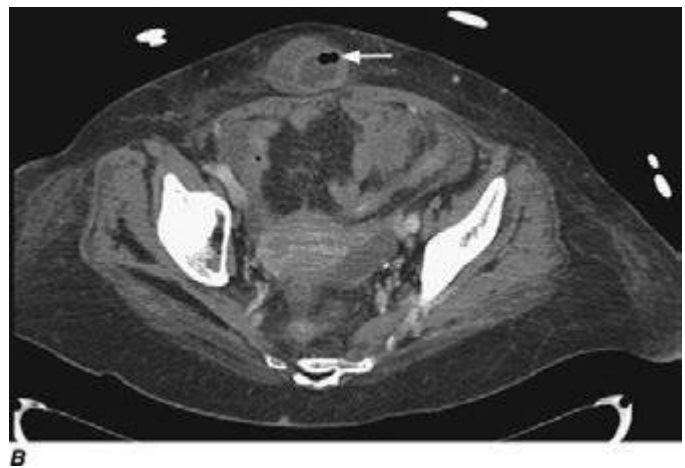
Computed tomography with oral and intravenous contrast demonstrating (A) evidence of small-bowel dilatation with air-fluid levels consistent with a small-bowel obstruction; (B) a partial small-bowel obstruction from an incarcerated ventral hernia (arrow); and (C) decompressed bowel seen distal to the hernia (arrow). (From W Silen: *Acute intestinal obstruction*, in DL Longo et al [eds]: *Harrison's Principles of Internal Medicine*, 18th ed. New York, McGraw-Hill, 2012.)
